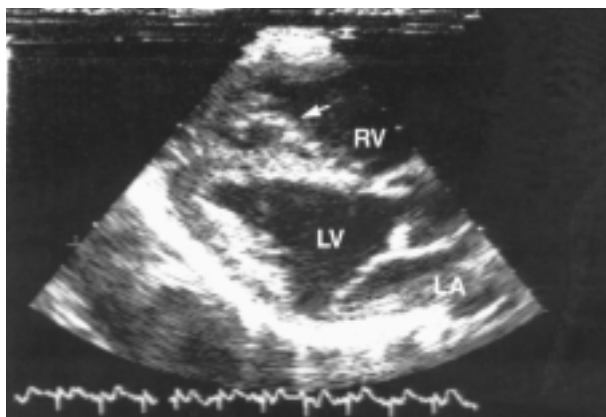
Echocardiography (parasternal long axis view) demonstrates a mass filling the right ventricular apex extending to the tricuspid valve apparatus (arrow). LA = left atrium; LV = left ventricle; RV = right ventricle.
